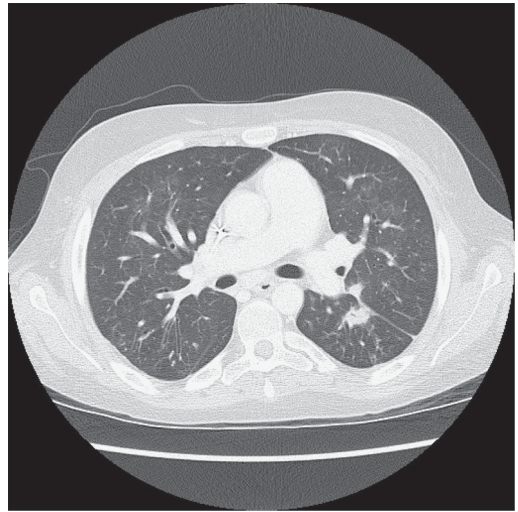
Chest CT showing a nodular infiltrate in the left lung without cavitation or pleural effusion.
